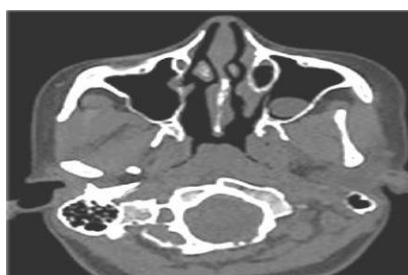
Axial noncontrast computed tomography image in bone window showing polypoidal mass arising from lateral wall of the left maxillary sinus
